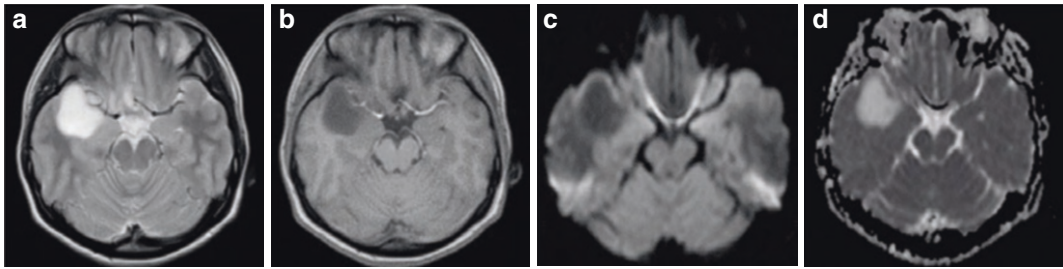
IDH-mutant oligodendroglioma, WHO grade II. A 26-year-old female patient whose MRI shows an abnormal circular lesion in the right temporal lobe with homogenous signal intensity. Transverse T₂WI shows
